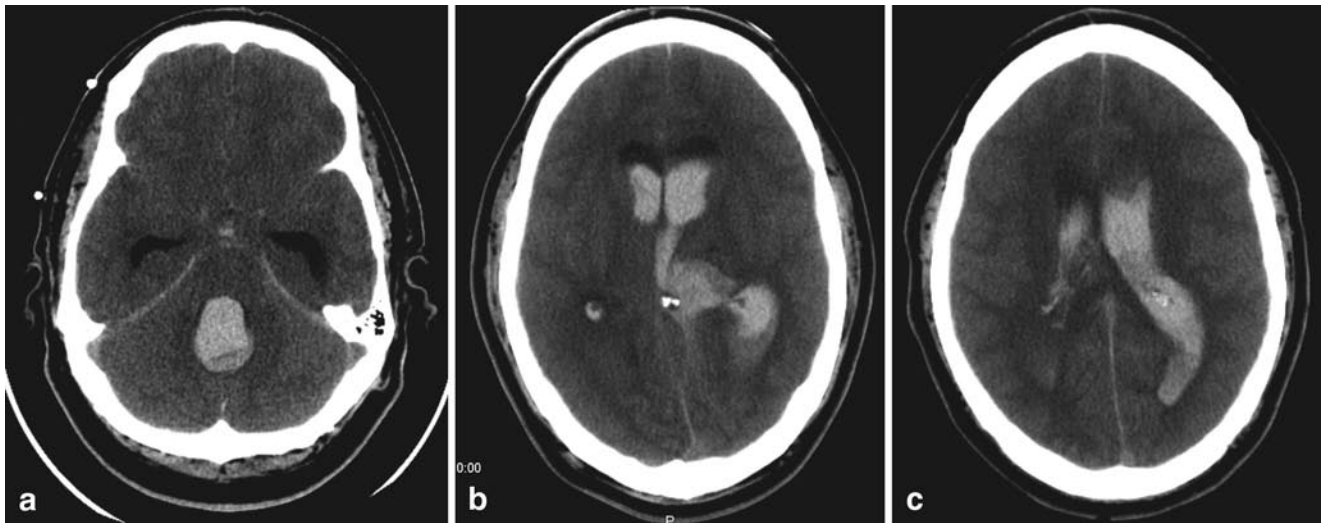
Head CT scan showing an intraparenchymal hematoma in the left thalamus (b) with massive rupture into the ventricular system (a, c)
